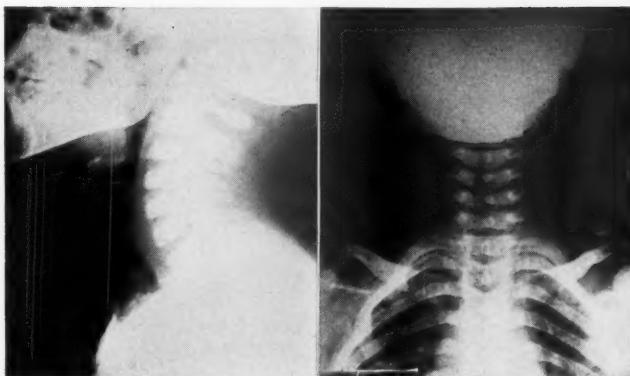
Antero-posterior and left lateral x-rays of the neck on the third postoperative day. Minimal amounts of air are in the fascial planes of the neck and absence of retro-tracheal thickening are demonstrated.
